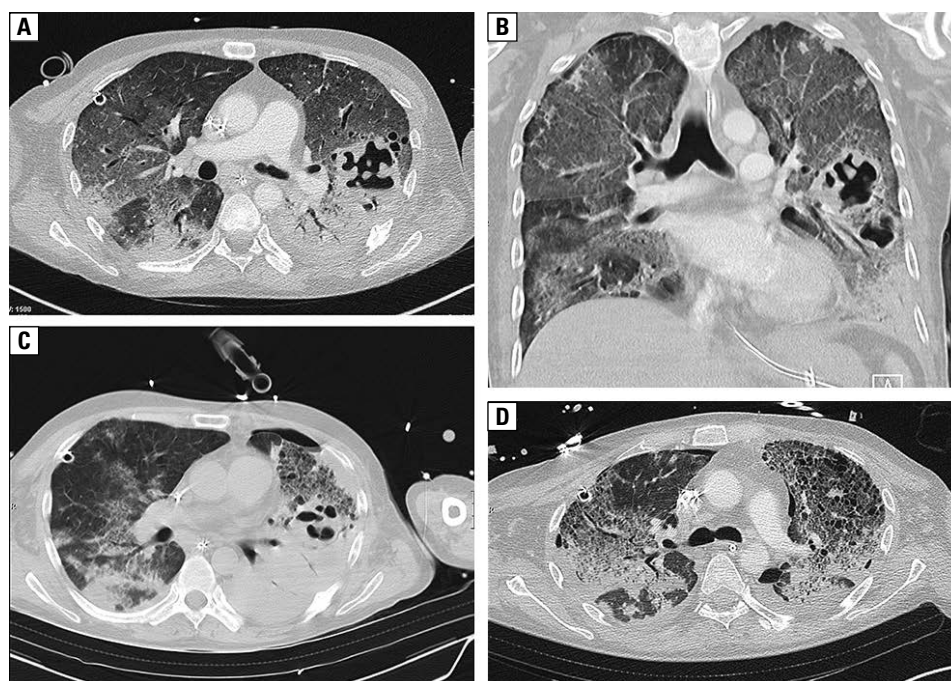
A — chest computed tomography (coronal reconstruction) diffuse bilateral ground-glass opacities; multiple small diffuse patchy consolidations in the lungs. A large dense opacity at the lower left pulmonary lobe. Two cavitations (abscesses) with thick walls and irregular inner edges in the medium-basal zone of the left pulmonary lobe; B — chest computed tomography (axial reconstruction) pulmonary dense opacities associated with reticular opacities, small pleural effusion and small pneumothorax in the left pulmonary lobe. Diffuse patchy opacities associated with ground-glass opacities and small pleural effusion; C — chest computed tomography: small pneumothorax, reduction of pulmonary consolidation. Ground-glass opacities associated with bullous-cystic areas in the left lower lobe. Ground-glass opacities associated with patchy opacities and small pneumothorax in the right lower lobe
